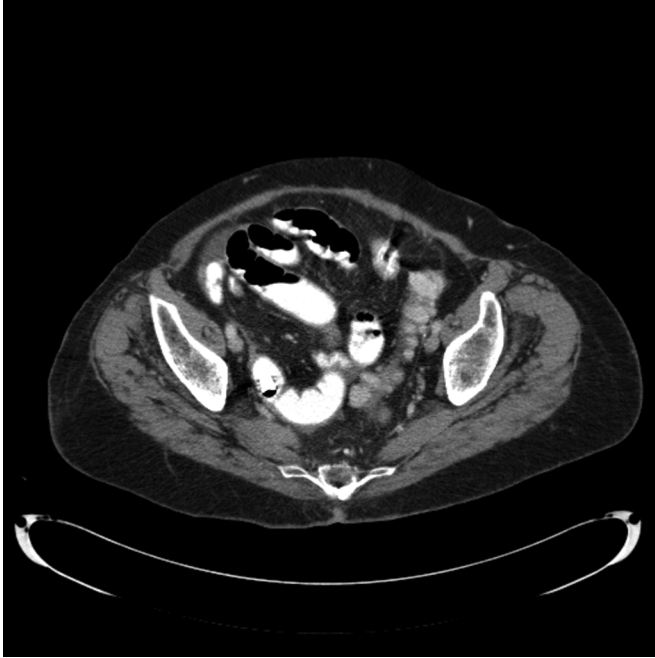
CT scan demonstrating retained video capsule in terminal ileum.
